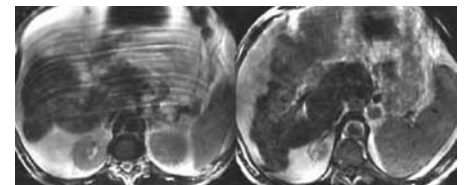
A non breath-hold FSE T2-weighted image (FSE TR 4100, TE 99), left, of a patient with cirrhosis and ascites, is degraded by respiratory and motion artifact. A breath-hold version of T2-FSE (TR 2000, TE 99), right, has similar T2 contrast but little motion or respiratory
